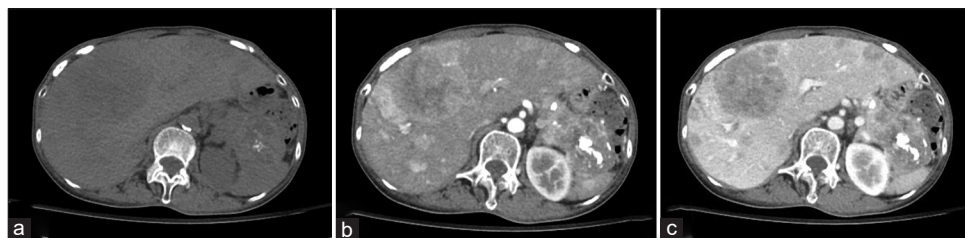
Radiologic findings of a pancreatic alpha-fetoprotein-producing neuroendocrine carcinoma with liver metastasis. (a) Precontrast computed tomography (CT) image. (b) Contrast-enhanced arterial phase of the CT scan. (c) Contrast-enhanced venous phase. CT scan showed an 8.2 cm \times 5.5 cm pancreatic tail tumor with calcification and multiple liver metastases. CT: Computed tomography
